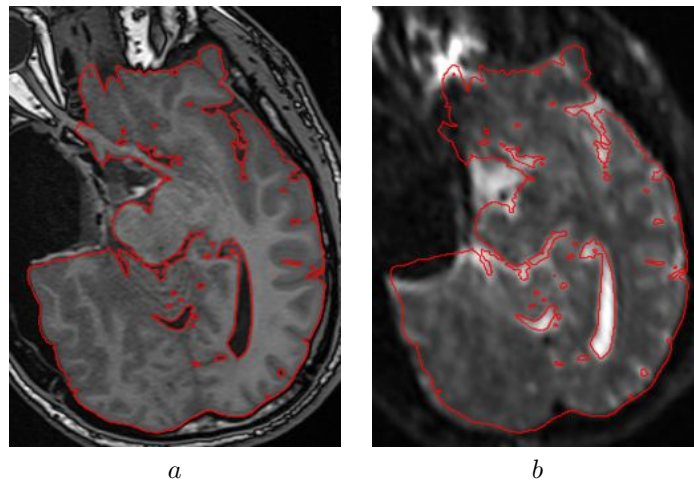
Images showing the effect of susceptibility artefacts on interventionally acquired EPI image. (a) shows the susceptibility artefact free T1 weighted MRI image with the edges highlighted by red boundary. (b) shows the corresponding EPI image. Large deformation around the area of resection is evident.
